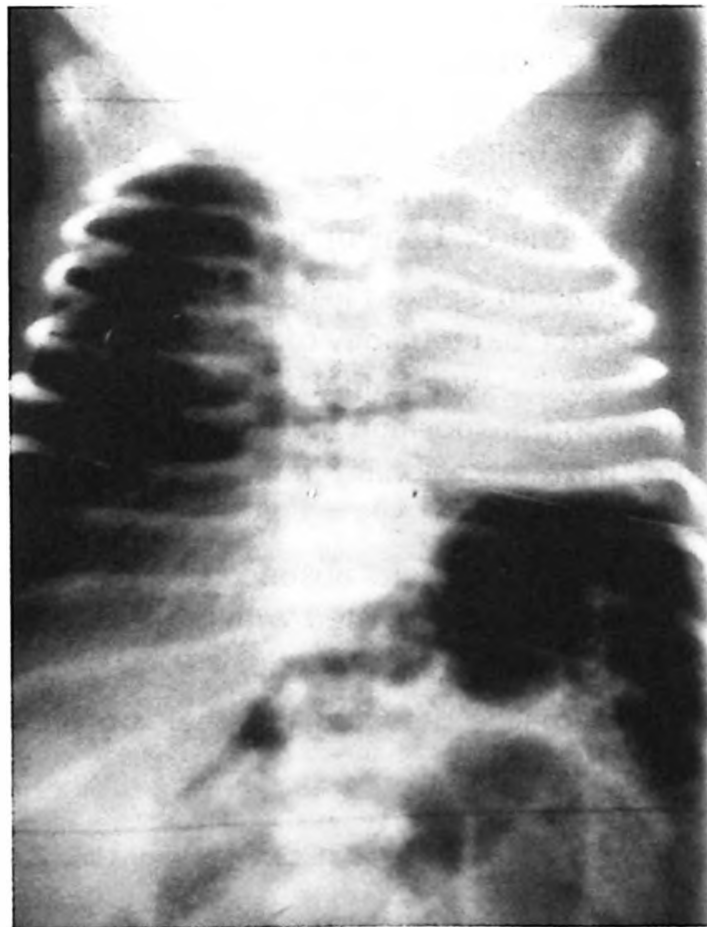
The chest roentgenogram of the patient showing dense left hemithorax.
